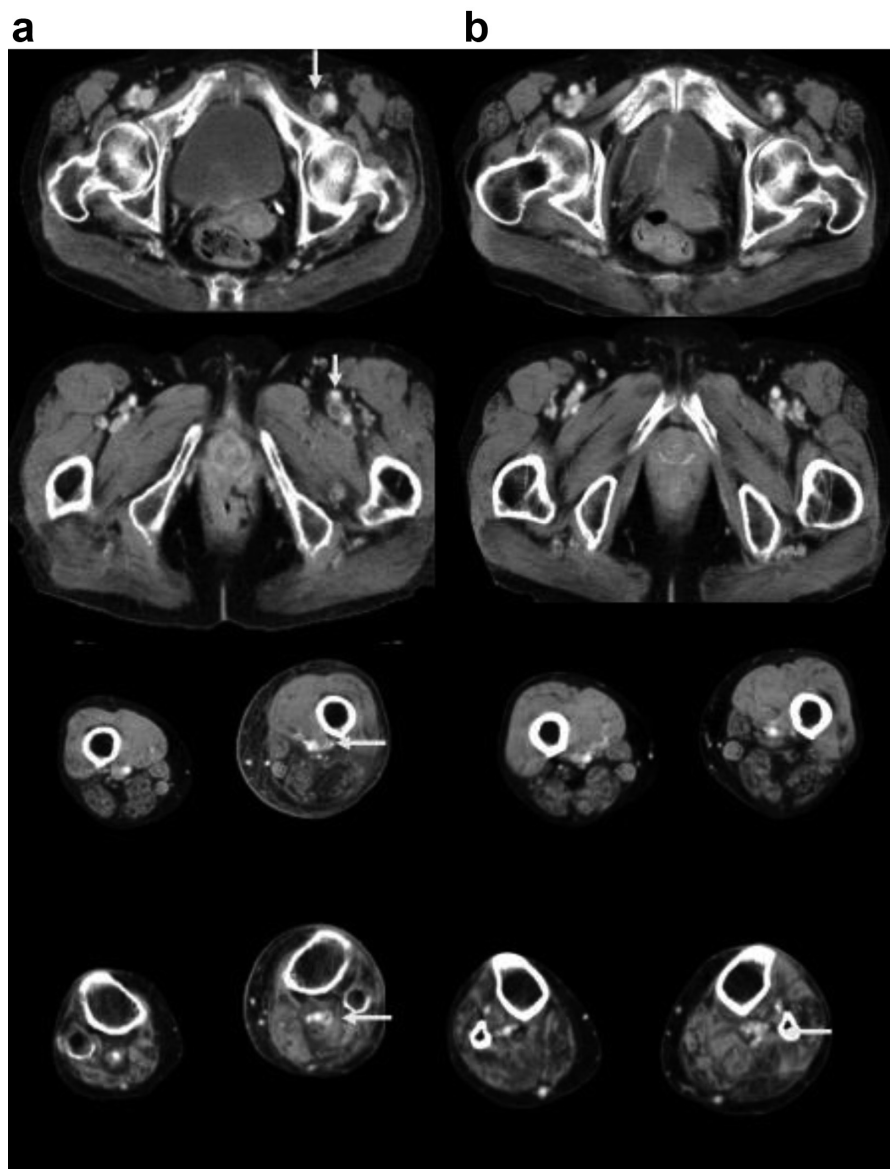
Contrast enhanced computed tomography (CT) showed that a burden of deep vein thrombosis (DVT) decreased drastically after treatment. The left side of the figure (Figure 1a), taken at time of diagnosis, shows the presence of a large DVT from the left iliac vein to the left popliteal vein. The CT on the right side of the figure (Figure 1b) was taken on day 117 of treatment and shows that the DVT has almost disappeared apart from a slight DVT below the left popliteal vein.
